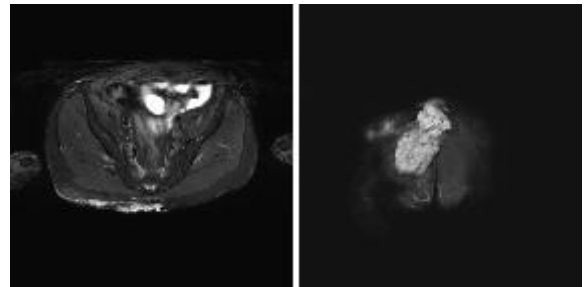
Magnetic resonance imaging (MRI) of the sacral region demonstrating a protruding soft tissue tumor arising from a chronic burn scar. The axial view (left) and coronal view (right) show a mass with dermal infiltration and strong contrast enhancement without definite extension into the underlying muscle or fascia.
